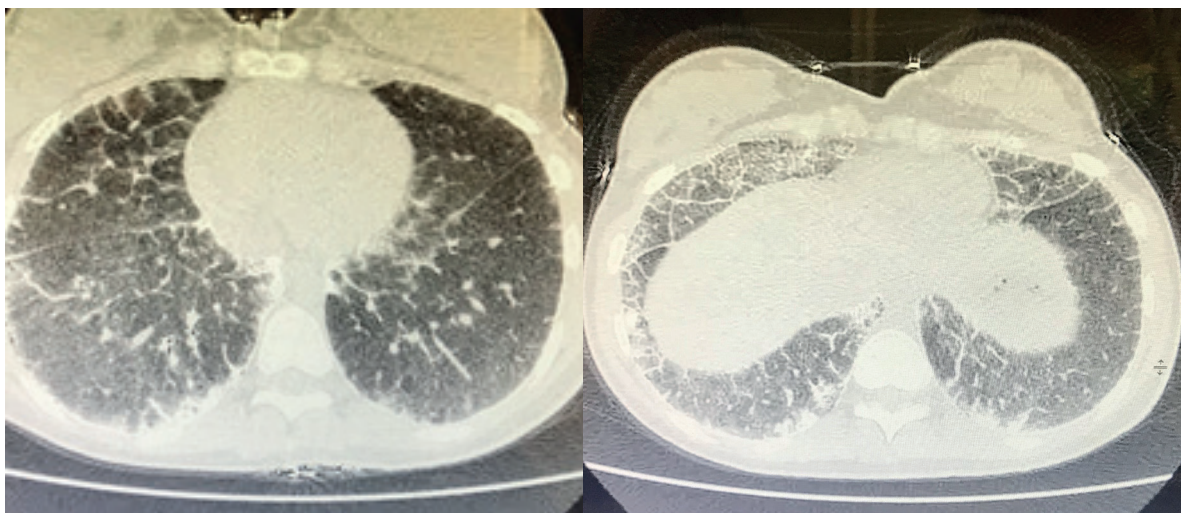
The computed tomography scan shows multiple calcified micro nodules that scanned when she was 17 years old.
